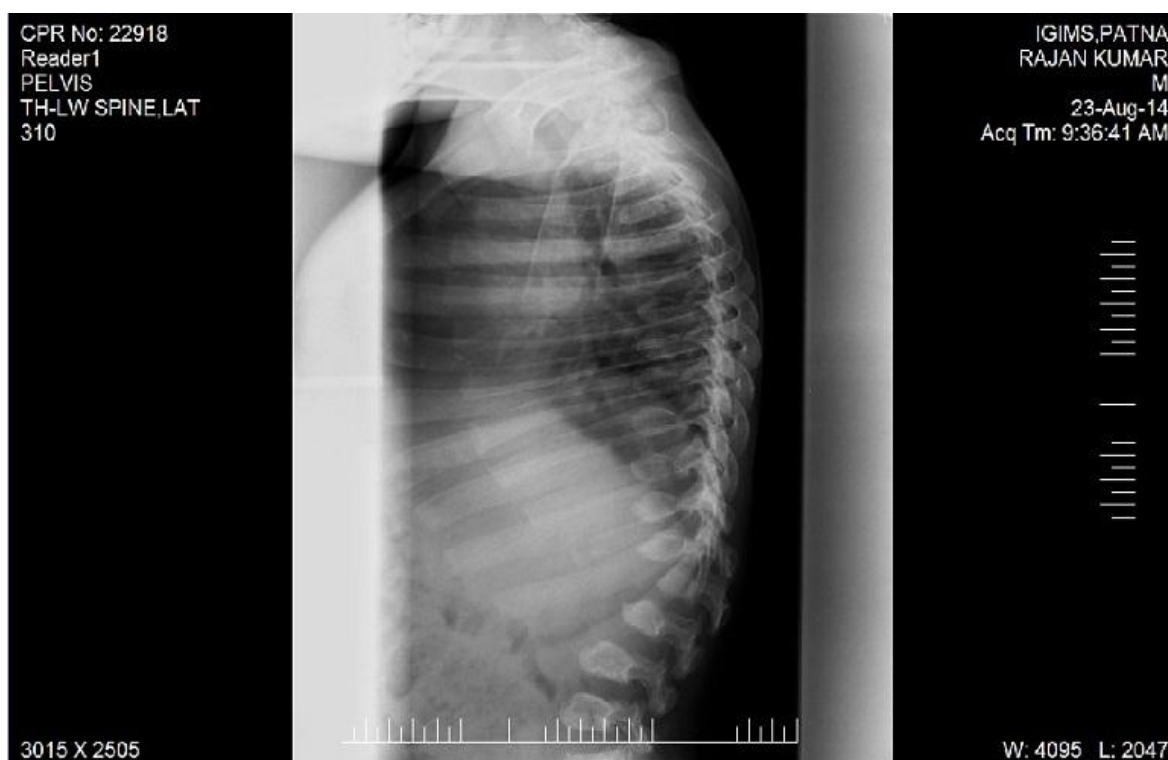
9-X-ray of thoracolumbar spine showing typical antero-inferior beaking of vertebral bodies and severe kyphosis at lumbar region.
